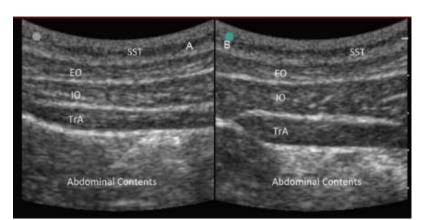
Ultrasonographic images of transverse abdominal, internal oblique, and external oblique muscles, at rest (A) and contraction (B)
